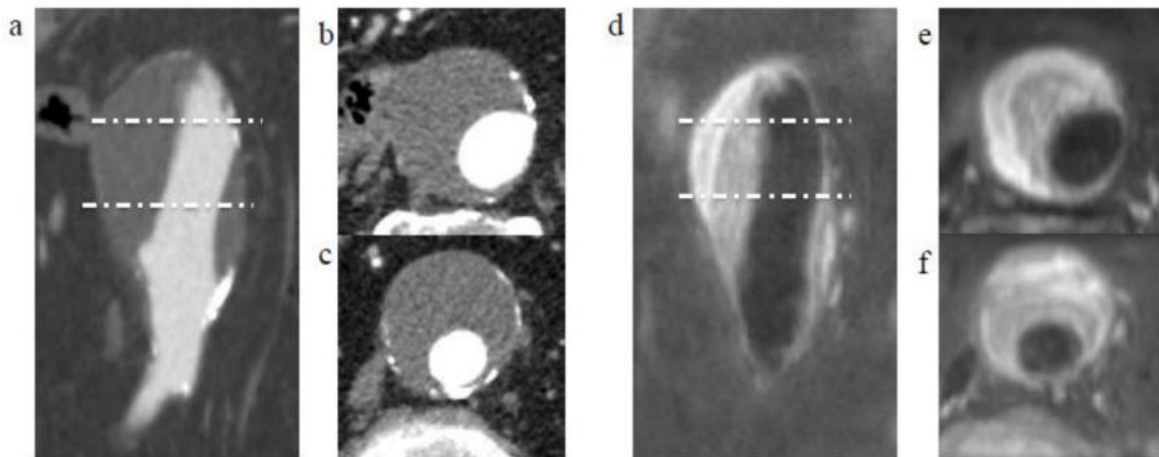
Comparison of CTA images (left) and FSE T₁-weighted images (right) in an AAA patients with intraluminal thrombus (ILT). Coronal (a, d) and two axial slices (b-c, e-f) at identical locations are shown. (Reproduced from Zhu *et al.* ¹⁷¹, with permission from Elsevier)
